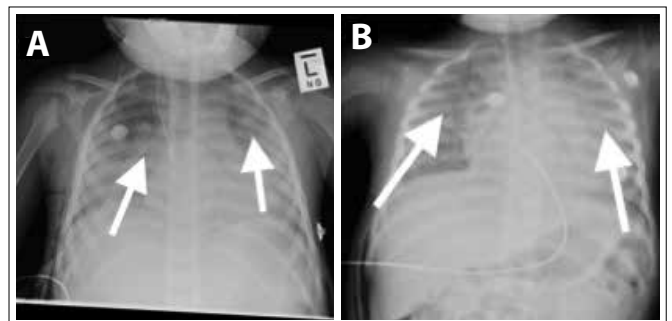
Frontal chest X-rays of a patient with idiopathic pulmonary haemosiderosis (A and B). X-rays depict bilateral diffuse reticular infiltrates (white arrows) that involve both lung fields. (Courtesy of Dr D Parris, Department of Paediatrics and Child Health, Steve Biko Academic Hospital)
